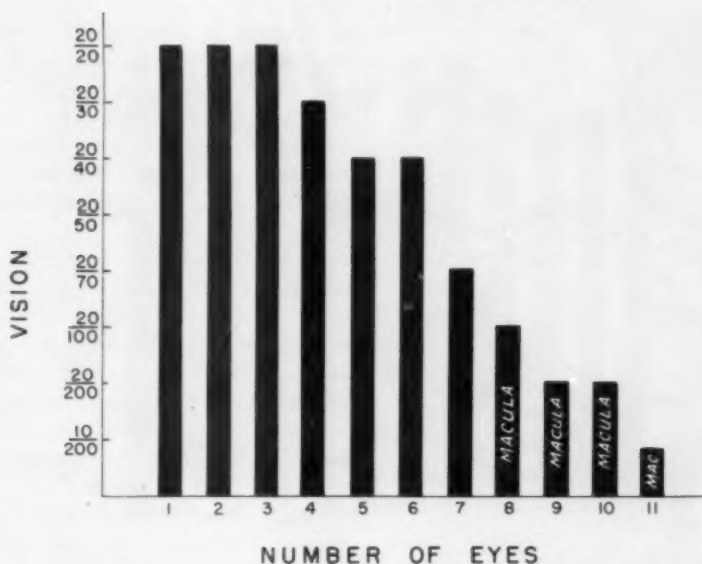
(Reese, Hyman, Merriam, and Forrest). The vision of the 11 patients with arrested disease by X-ray therapy. The four patients with the poorest vision had macular involvement by the tumor.
